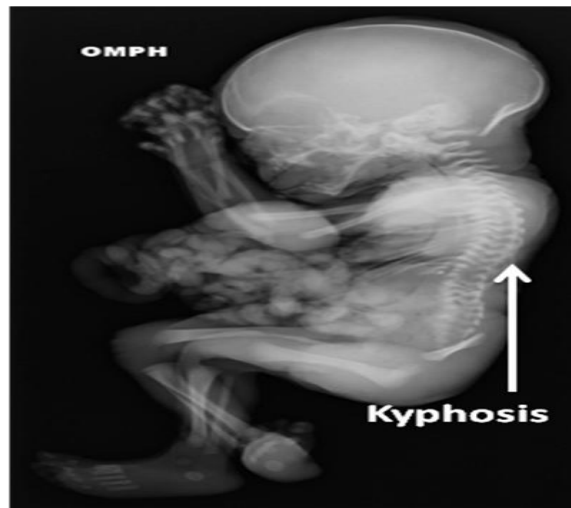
X-ray showing Kyphosis.
